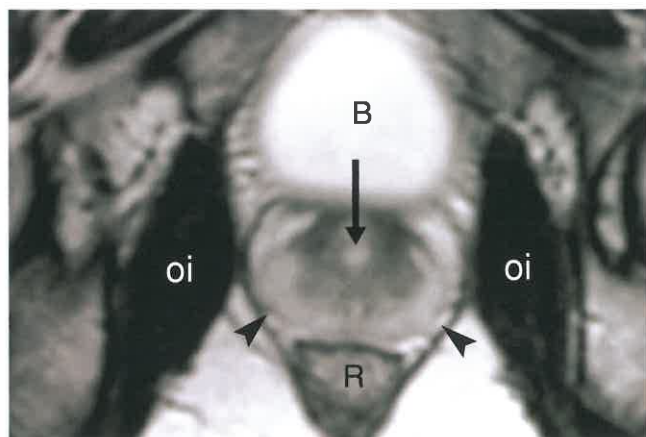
Normal Prostate—MR. Axial plane T2-weighted MR of a normal prostate in a 40-year-old man demonstrates the high-intensity peripheral zone (arrowheads), the urethra (long arrow), and the lower-intensity transitional zone surrounding the urethra. B, bladder; R, rectum; oi, obturator internus muscle.
